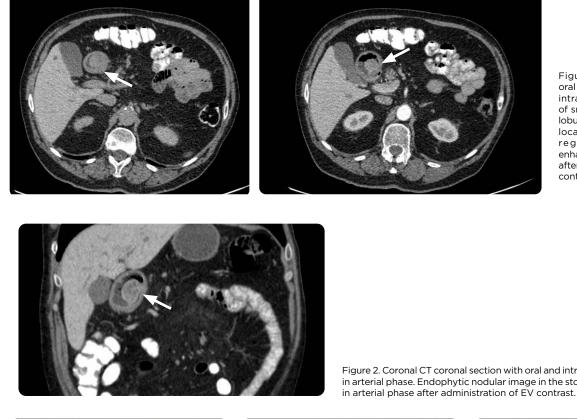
Axial CT. a) With oral contrast medium and b) intravenous. Nodular image of smooth borders, discretely lobulated, endophytic (arrow), located in the anthropiloric region, which presents enhancement in arterial phase after the administration of EV contrast medium.
